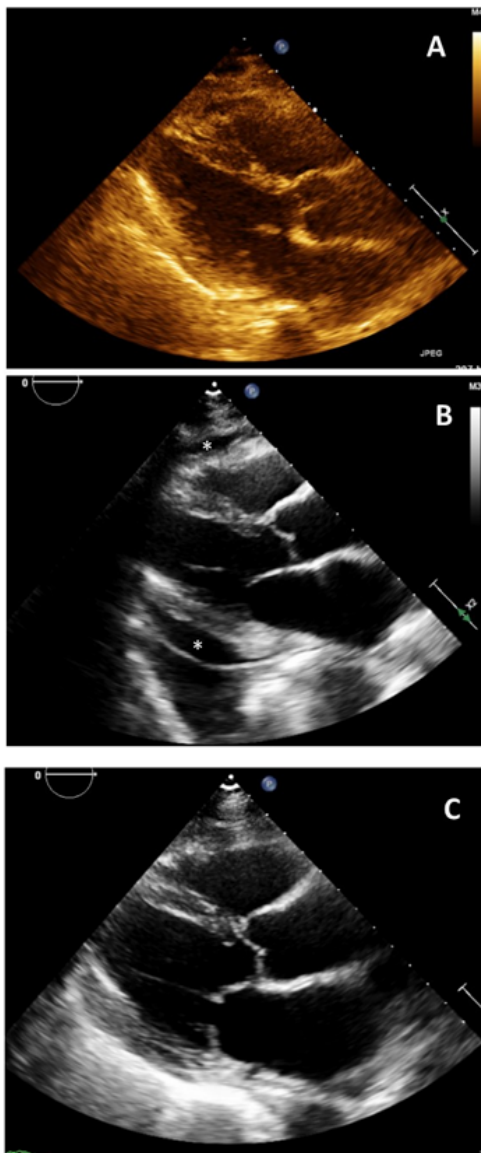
Transthoracic Echocardiogram (TTE). Parasternal Long axis view.
